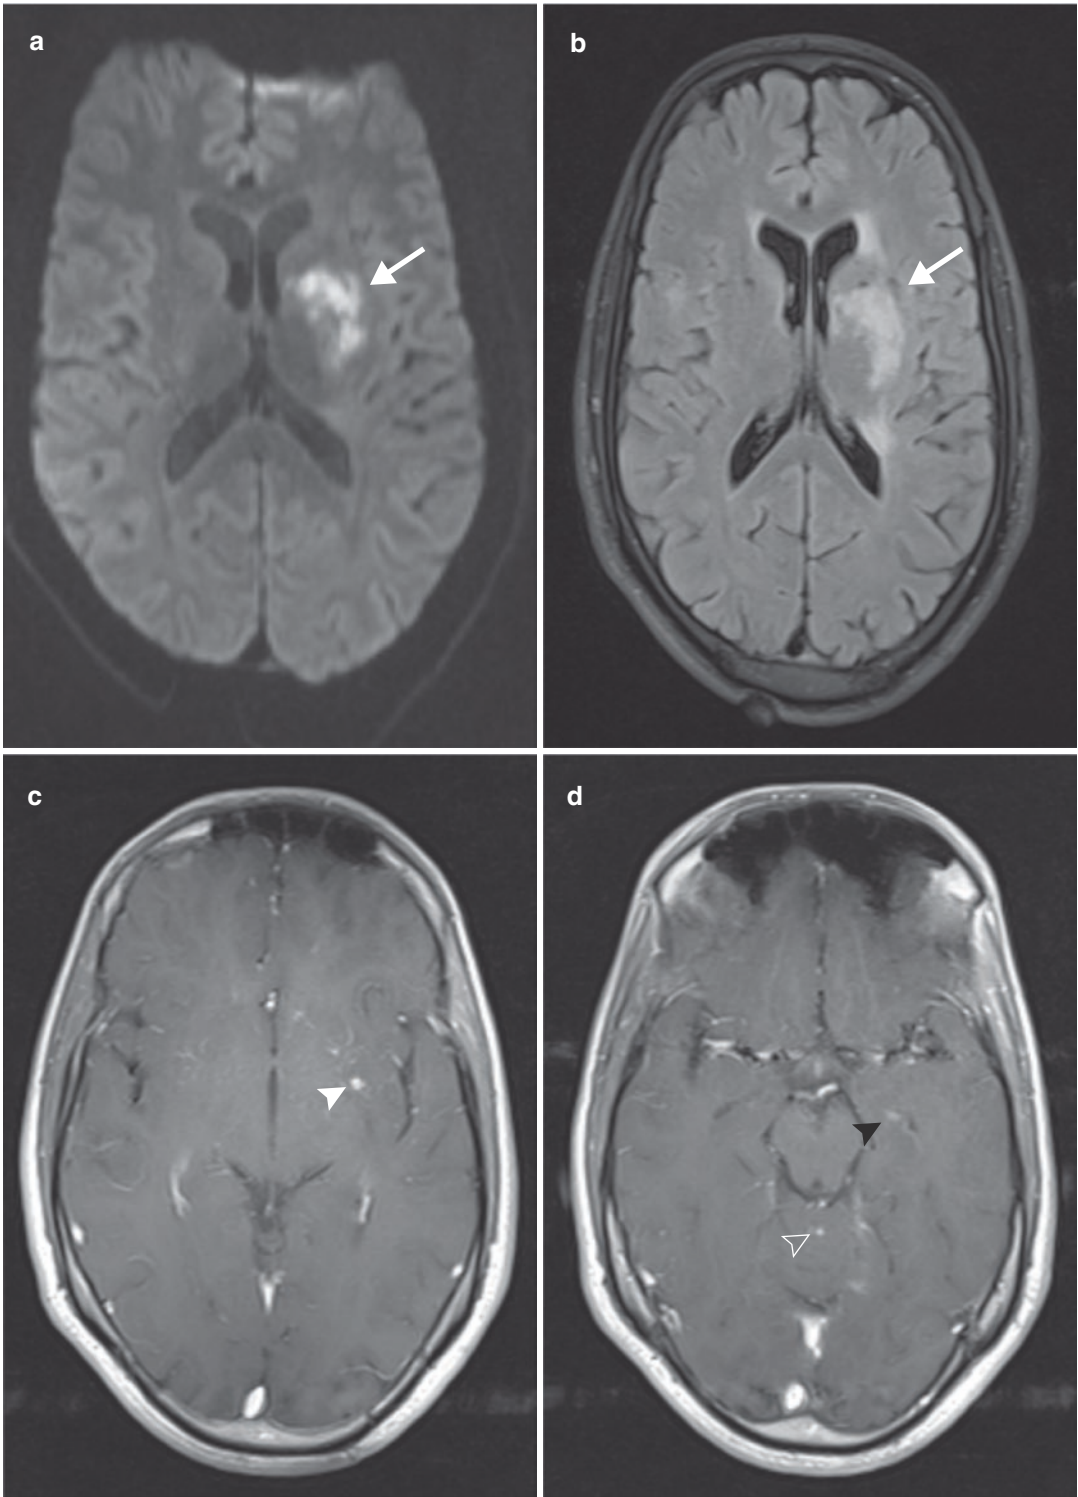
Tuberculous basal ganglia infarction. Axial (a) diffusion-weighted and (b) axial FLAIR MR images show restricted diffusion with FLAIR hyperintensity in the left basal ganglia, consistent with a recent infarct (white arrows). (c and d) Axial contrast-enhanced T1-W MR
